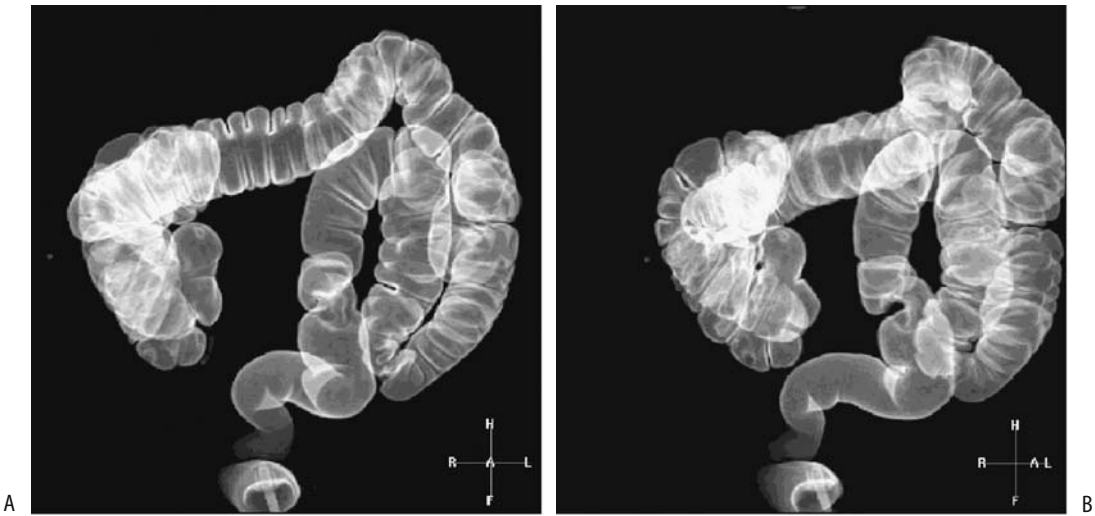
A,B: Two 3D double-contrast MR virtual colonoscopy images. Visualization is similar to that obtained with CT (see Fig. 5.1). (Courtesy of Wolfgang Luboldt, M.D., Johann Wolfgang Goethe University, Frankfurt-am-Main.)
